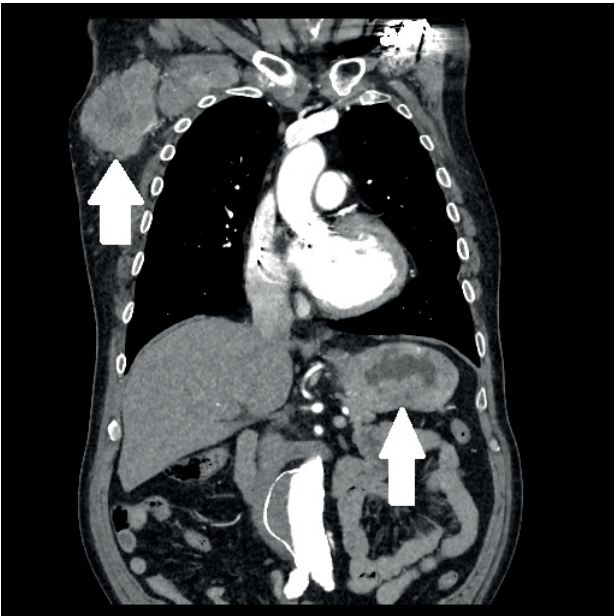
Coronal CT images showing the large right axillary mass and thickened irregular gastric wall.
